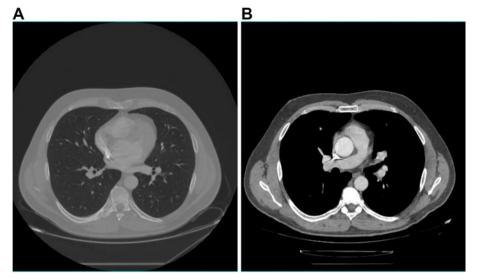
A: HRCT (normal findings). B: CT pulmonary angiogram (normal findings).
